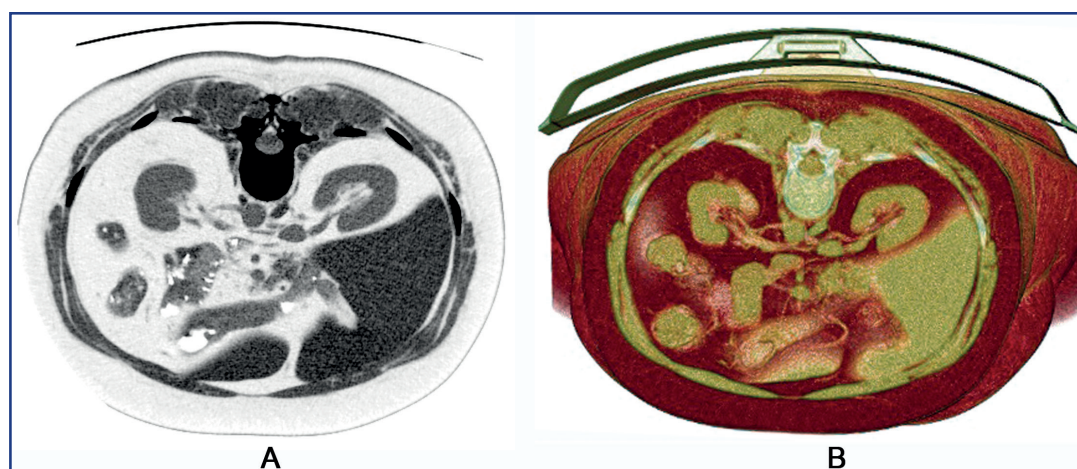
CT of kidney and kidney vessels in a patient with AML before (A) and after (B) Allo HSCT
